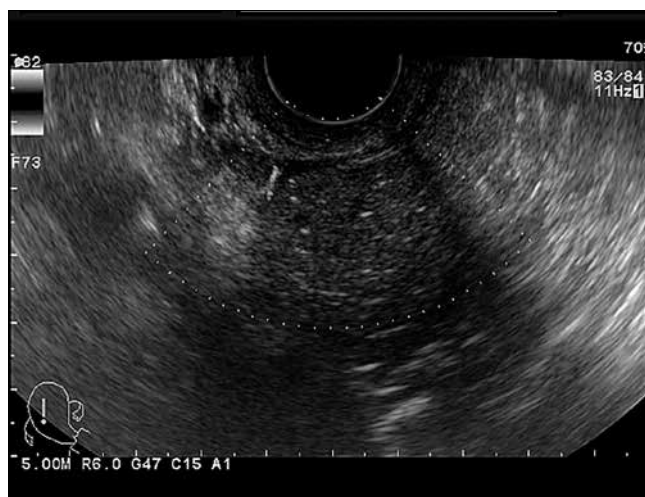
False negative result of ultrasonography in 63-year-old woman with serous adenocarcinoma.
